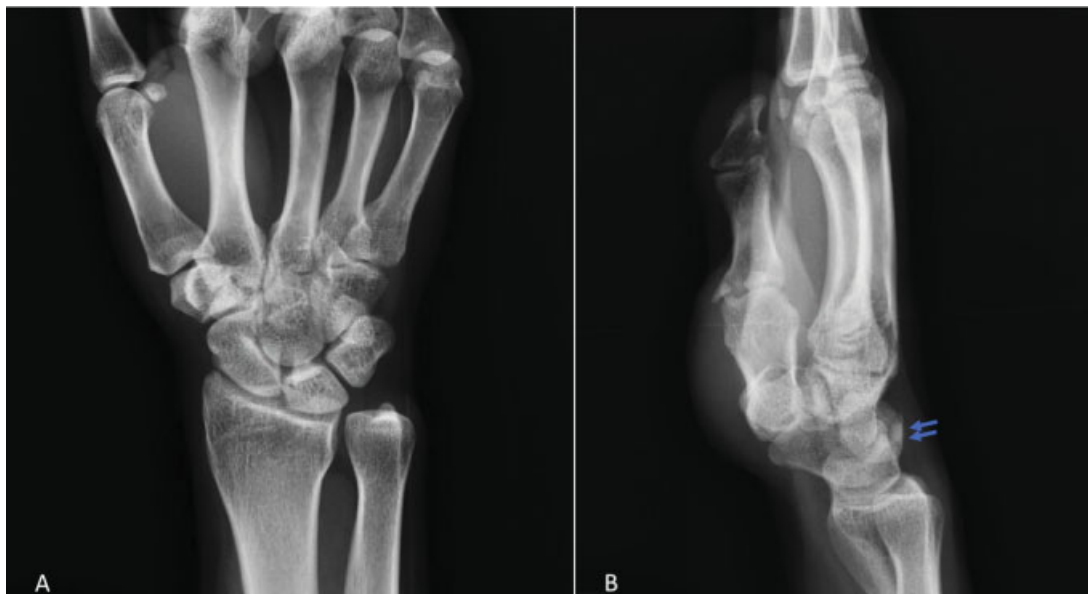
(A-B) Anterior-posterior and lateral wrist radiographs, with arrows indicating dorsal wrist mass.
